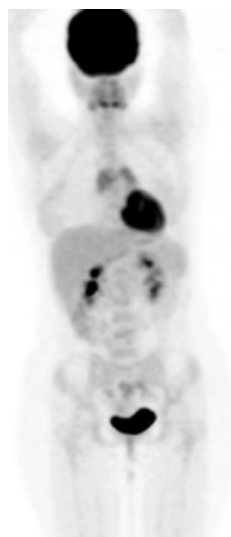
The anterior mediastinal mass on the CT and PET-CT (transaxial, vertical and coronal sections) scan of patient after 3 months from the chemotherapy that indicates thymic hyperplasia
